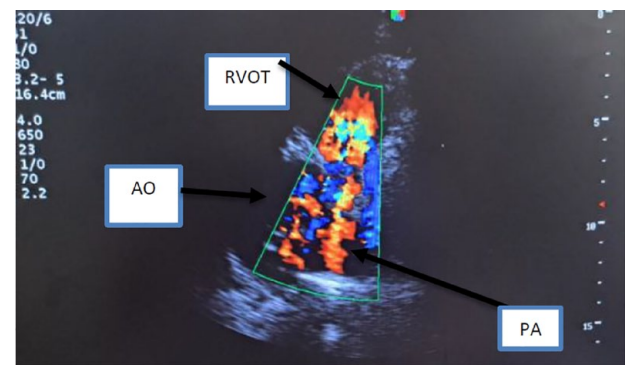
Parasternal short axis view at the great vessels level: color flow doppler at the pulmonary valve showing turbulent flow showing both pulmonary regurgitation and pulmonary stenosis.
